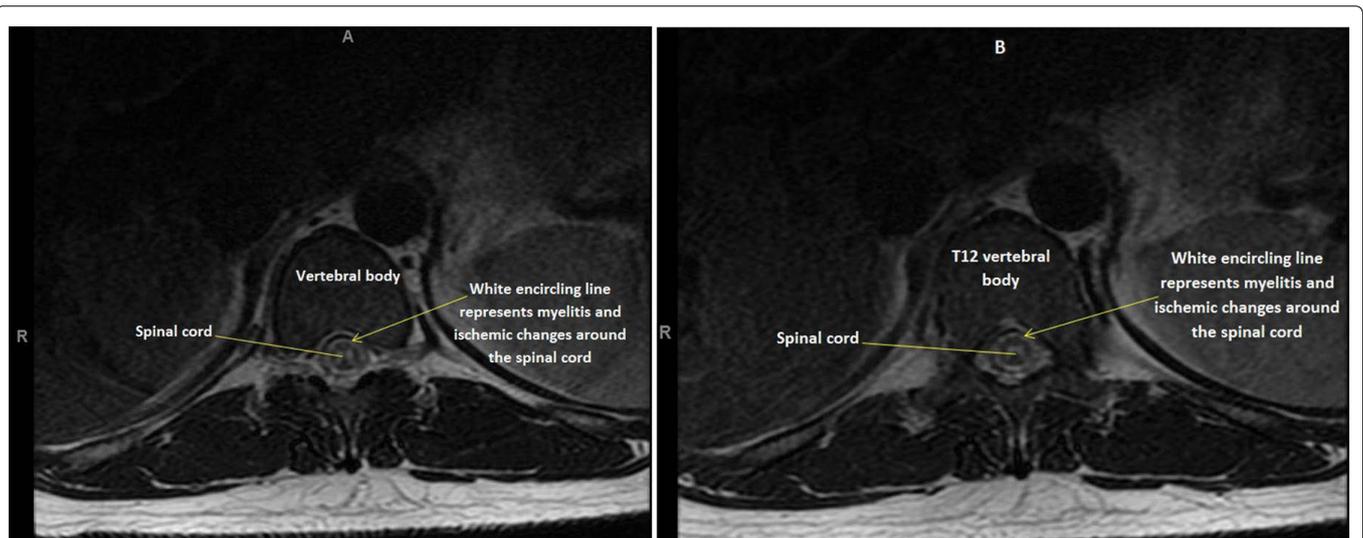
A,B) This figure displays MRI image at the level of T12 and L1 vertebrae. Myelitis is shown around the spinal cord as white encircling line. Patient suffered paraplegia which prompted us to do the MRI thoracic spine.
